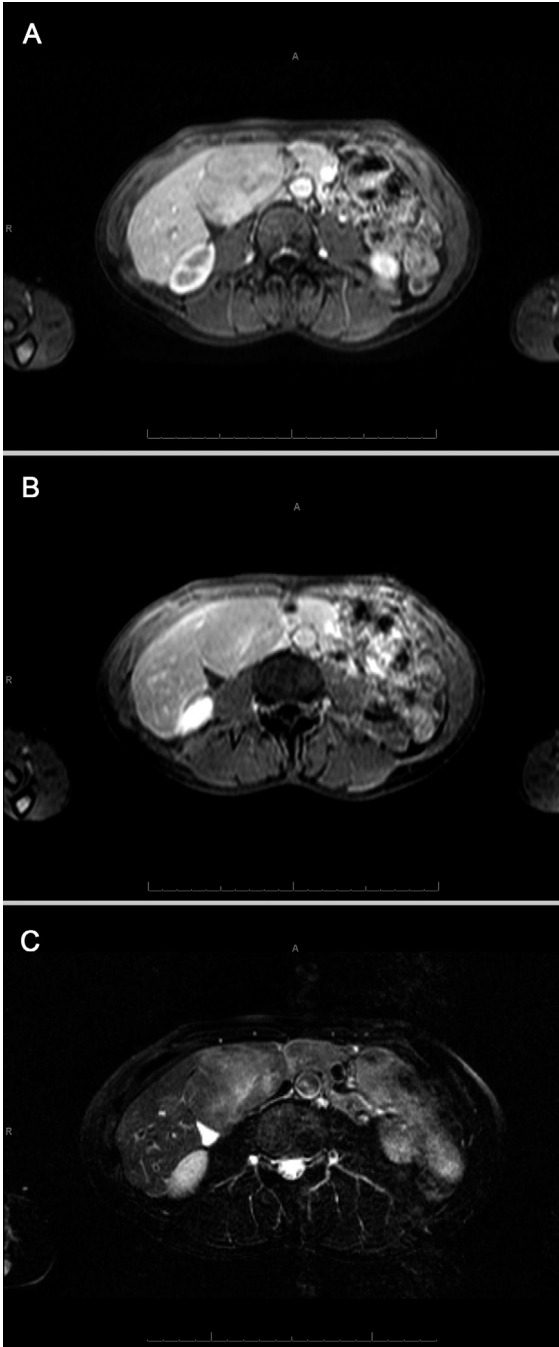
Transverse (a) arterial- and (b) late vascular-phase T1-weighted dynamic contrast-enhanced and (c) T2-weighted fat-saturated MR images show a β -catenin-positive HCA located in segment 4, with poorly delineated areas of increased signal intensity and a hyperintense scar on c. Lesion enhances irregularly on b.
